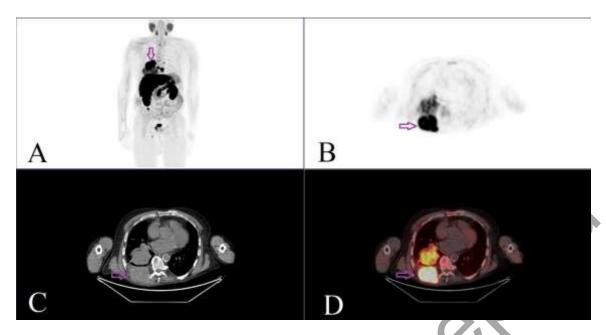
The arrow indicates increased FCH uptake in a tumor lesion (part of a pulmonary carcinoid) causing osteolysis of the VII and VIII ribs (SUVmax 15.7) (A – on MIP; B – on PET; C – on low-dose CT; D – on PET/CT).
